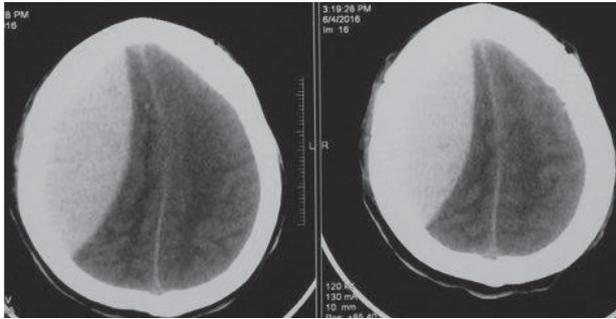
Axial plain CT scan of head showed right-sided epidural hematoma with mass effect.
